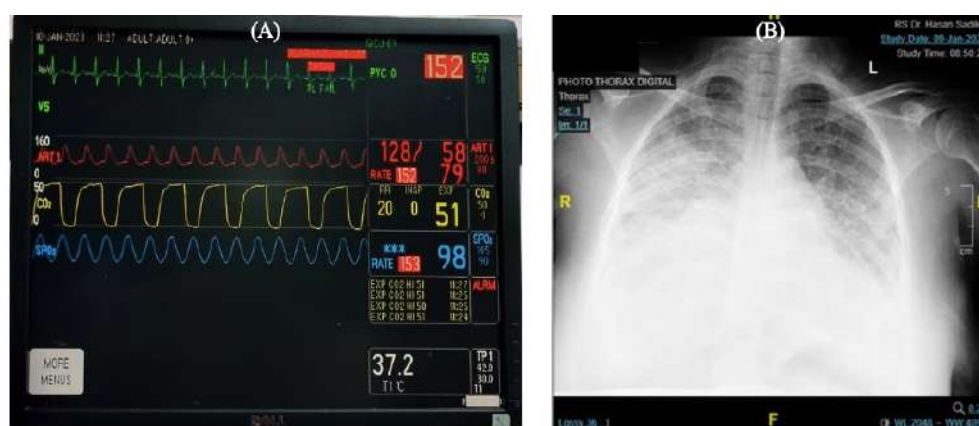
(A) Patient's hemodynamic status when first came to the ICU. (B) Patient's thorax X-Ray
